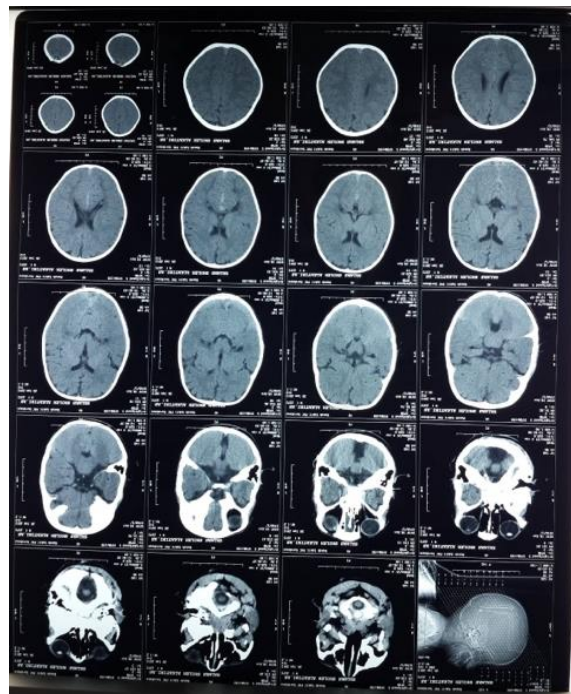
CT Scan of the patient's brain at the age of 12 months, with the results of an arachnoid cyst in the occipital region
